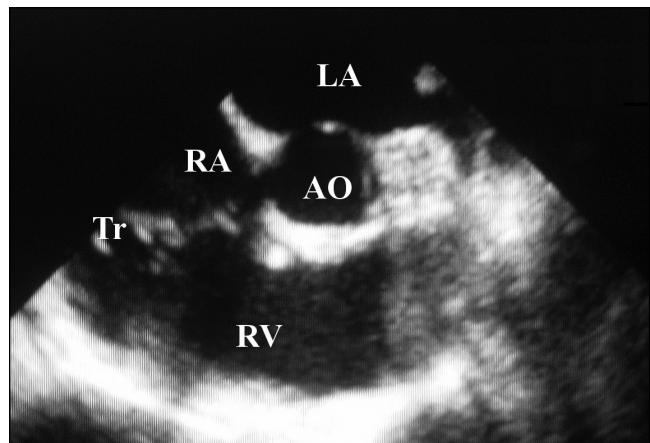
Control transesophageal echocardiographic image displaying regression of the size of the thrombus (Tr). AO Aorta; LA Left atrium; RA Right atrium; RV Right ventricle
